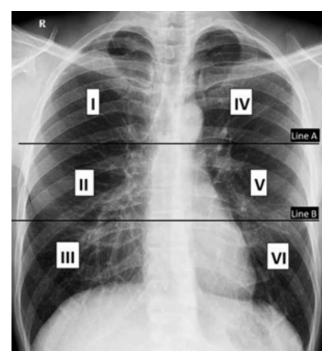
The Brixia Scoring System on the Chest X-ray.
